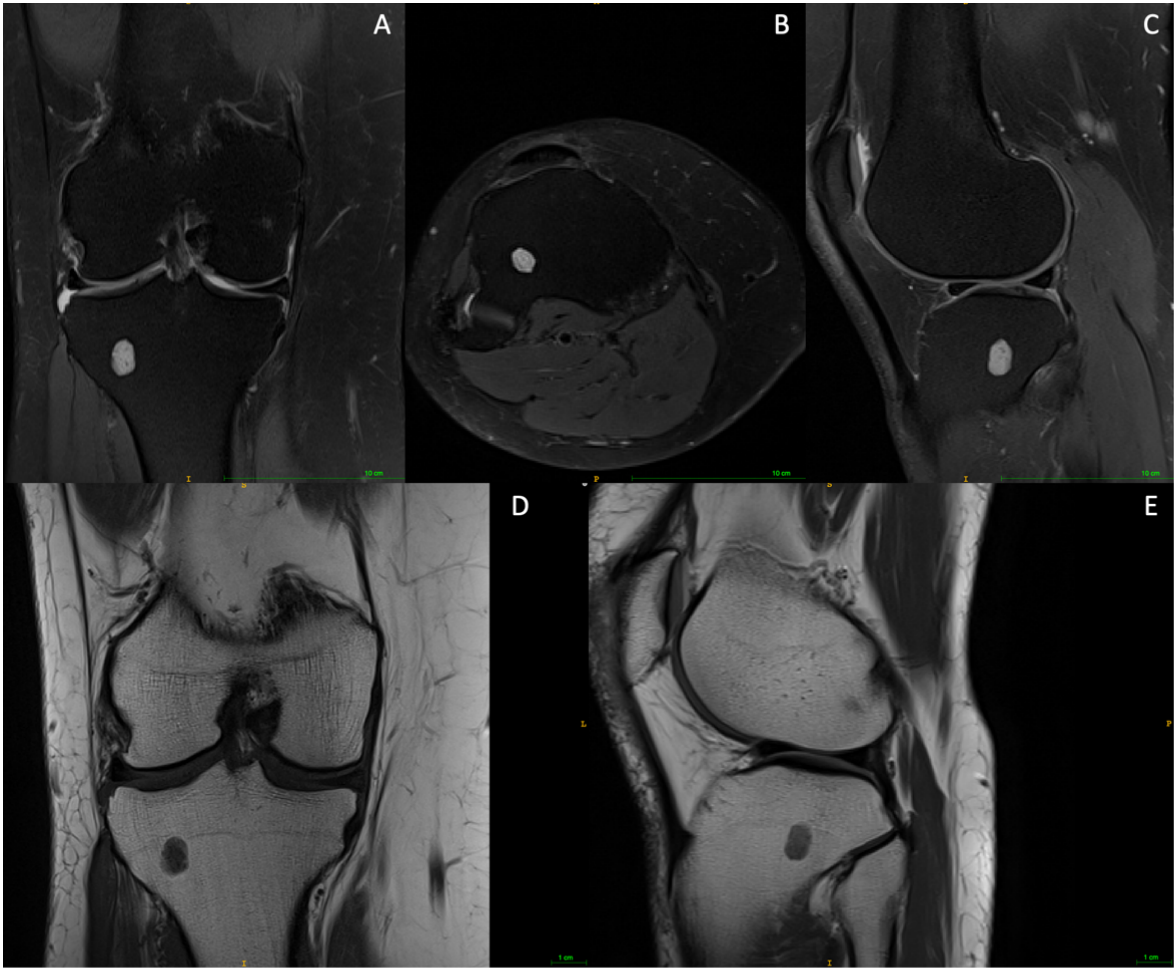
MRI of an enchondroma of the right tibia (female, 64 years): (A) proton density, fat suppression, coronal, turbo spin echo; (B) proton density, fat suppression, transversal, turbo spin echo; (C) proton density, fat suppression, sagittal, turbo spin echo; (D) t1, coronal, turbo spin echo; (E) proton density, t2, sagittal.
